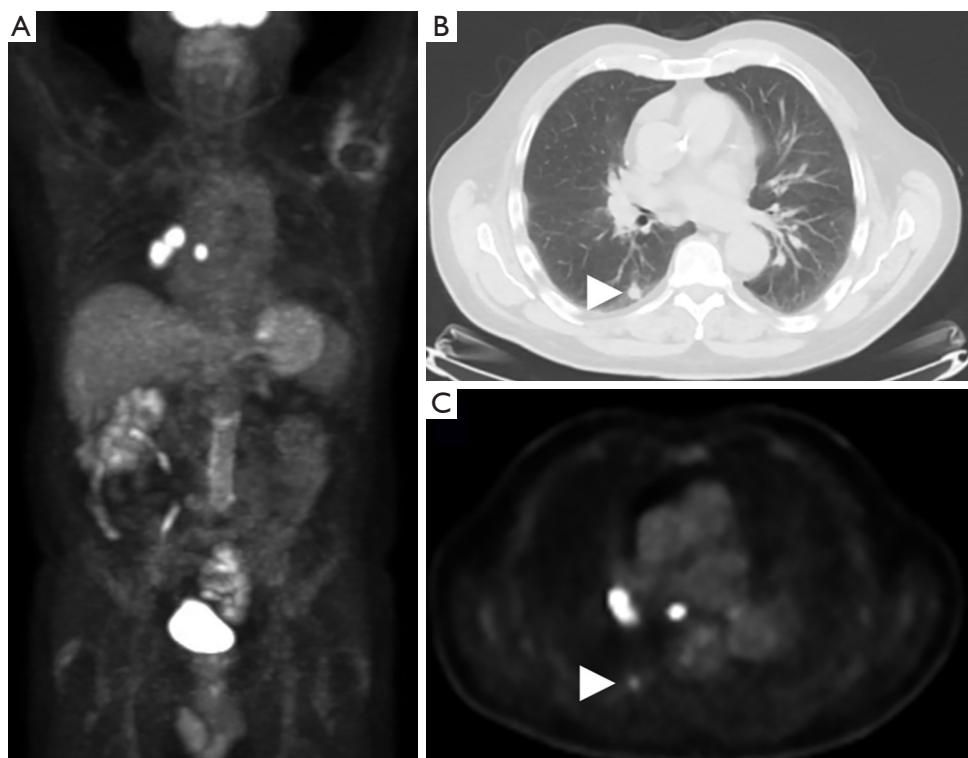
A 78-year-old female with a right lower lobe pulmonary nodule, incidentally seen on CT to assess aortic dissection repair, was further characterized with FDG PET/CT (A). Axial CT (B) and PET (C) images demonstrate a mildly FDG avid right lower lobe pulmonary nodule (arrowheads, SUVmax 2.2) and markedly FDG avid right hilar lymphadenopathy (SUVmax 13.6). Discordant degree of uptake within the nodule versus the draining lymphadenopathy is most consistent with an infectious etiology, specifically chronic fungal infection (so called “flip-flop-fungus” sign). Serological evaluation was positive for histoplasmosis.
